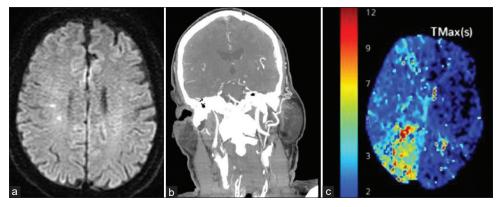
(a) Magnetic resonance imaging (MRI) of the brain was performed. Several acute diffusion-restricting right-sided infarcts noted through the MRI with diffusion-weighted imaging sequence. (b) Postsurgically, computed tomography (CT) angiogram of the neck and intracranial arterial circulation was obtained with Intravenous (IV) contrast. There is a clamp injury to the internal carotid artery and further dissection that was sustained from the CEA. (c) CT perfusion scan was performed which demonstrated a 42% penumbra in the right middle cerebral artery territory
